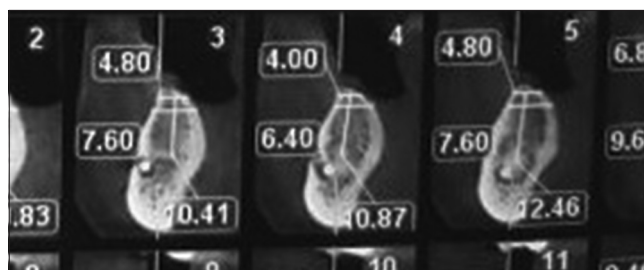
Cone beam computed tomography cross section of Case no 3 at dental implant site 35
